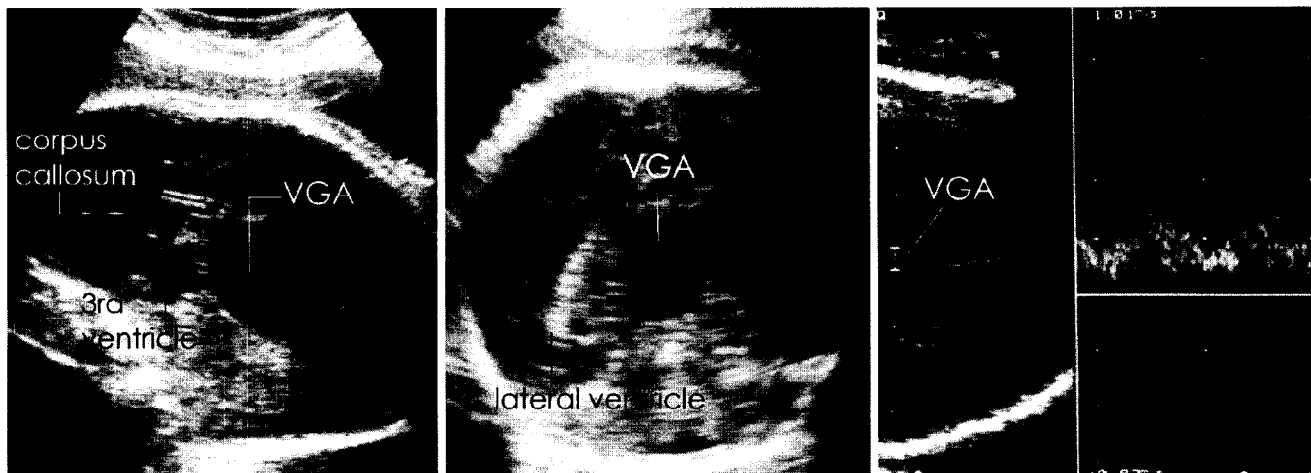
Case 21: in this fetus, sagittal and coronal scans reveal a cystic lesion at the level of the cistern of the vein of Galen. The diagnosis of aneurysm is confirmed by the pulsed Doppler demonstration of pulsatile blood flow within the lesion. The remaining intracranial anatomy appears unremarkable
